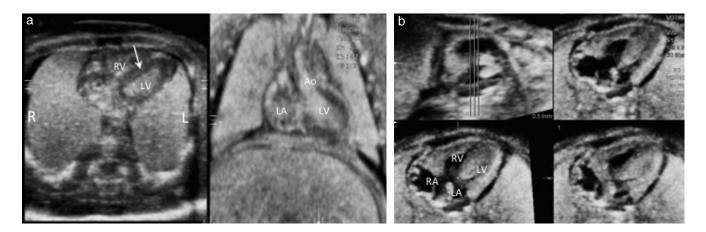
Postmortem ultrasound of fetal heart. Images were obtained using a linear probe (RSP 6-16). (a) Normal fetal heart in a 14-week fetus terminated for cystic hygroma; a normal cardiac axis and normal four-chamber view are visible, and the left ventricle (LV) is on the left side (L) and the right ventricle (RV) on the right side (R); the integrity of the interventricular septum is clear (arrow). The aorta (Ao) arises from the LV and is normally connected with the left atrium (LA). (b) Tomographic ultrasound images in a case of atrioventricular septal defect in a 15-week fetus terminated for Down syndrome. The four-chamber view demonstrates the crux of the heart in which the atrial and ventricular septal defects are located, as well as the single common atrioventricular valve.
